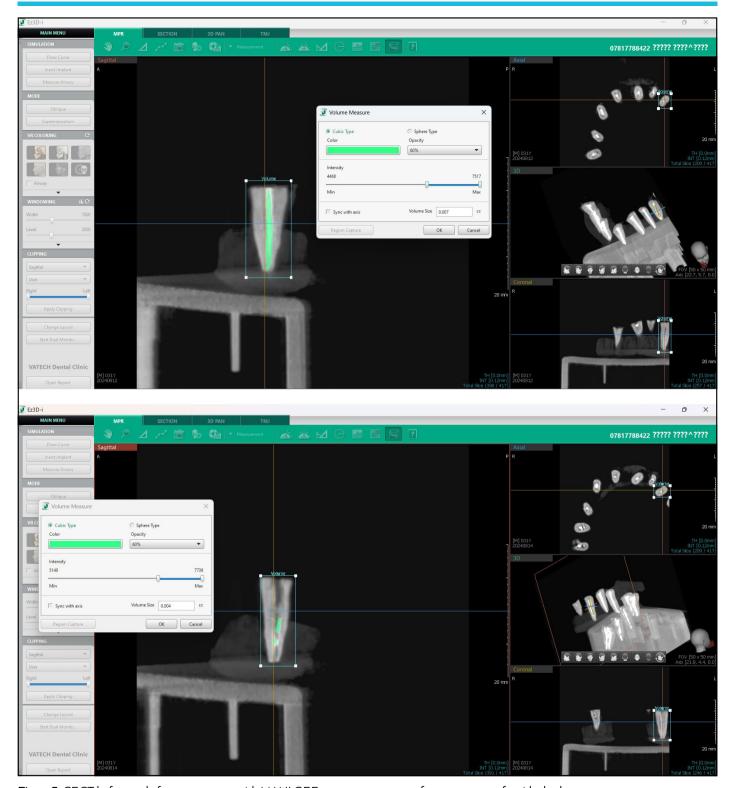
CBCT before and after retreatment with MANI GPR retreatment system for assessment of residual volume remanent. CBCT: Cone-beam computed tomography, MANI GPR: MANI gutta percha removal system.
